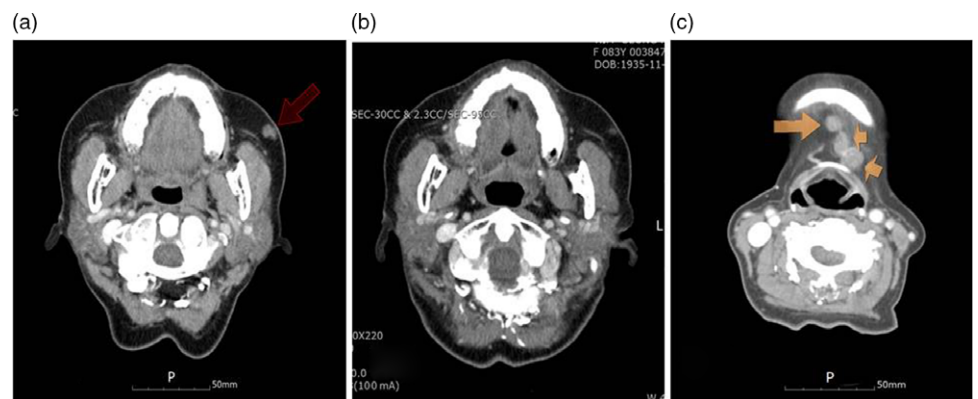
(a) CT before radiotherapy, an arrow showed subcutaneous lymph node. (b) CT at 3 months after radiation therapy, complete remission was achieved. (c) Small lymph node metastasis in left submental region after 1 year.
